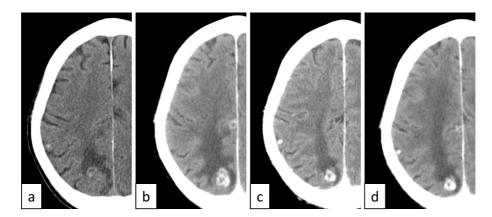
Computed tomography findings of the brain metastasis. a) Relapse of brain metastasis and carcinomatous meningitis. Whole-brain radiation therapy (WBRT) was initiated. b) One month after performing WBRT and just prior to crizotinib initiation, progression of the metastatic lesion was observed. A cytological analysis of the cerebrospinal fluid (CSF) was positive for malignant cells. c) One month after crizotinib initiation, the response of the metastatic lesion was observed. A cytological analysis of the computer of the metastatic lesion was observed. A cytological analysis of the response of the metastatic lesion was observed. A cytological analysis of the CSF was negative for malignant cells. d) One month after withdrawal of crizotinib, no remarkable change was observed.
